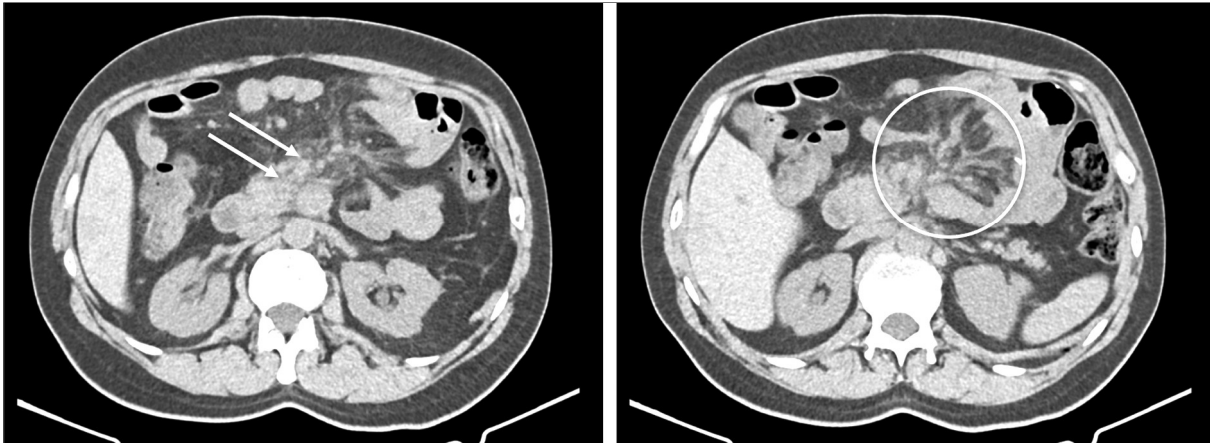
Axial reconstructed CT-scan images revealing a bulky mass was present in the mesenteric root (white arrows) with mesocolon and mesenteric retraction (white circle), with apparent colonic wall invasion
